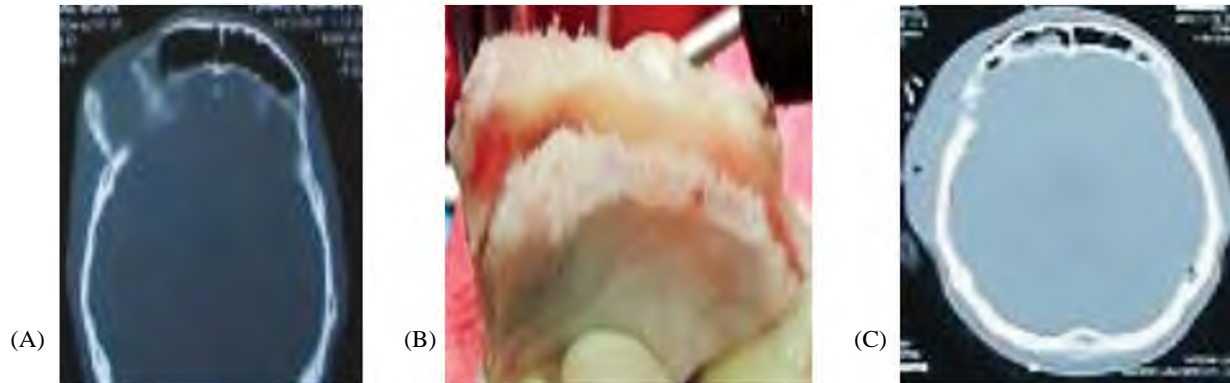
(A) Pre-operative CT bone window of axial cuts showing the skull defect. (B) Intra-operative image showing splitting of skull bone into two layers through the diploe. (C) Post-operative CT showing closure of the defect and correction of the deformity.
